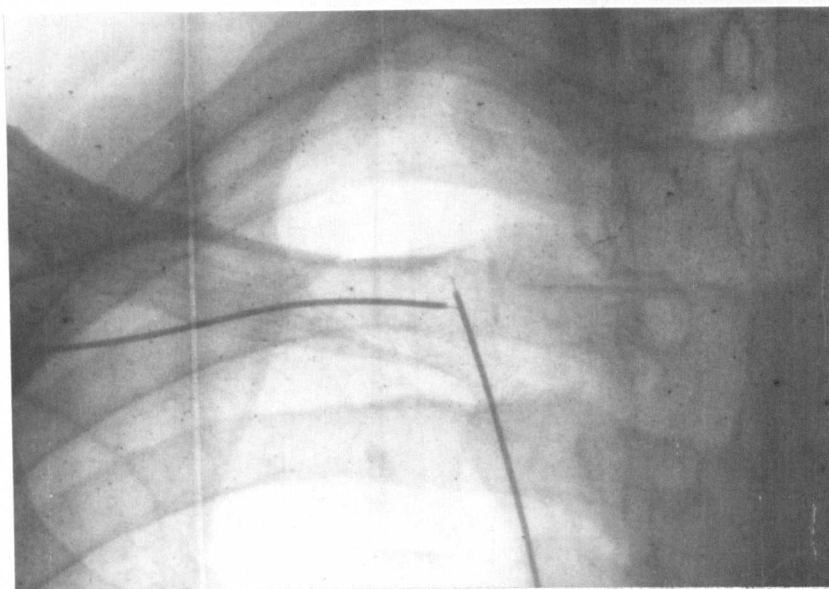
Radiograph showing broken unipolar endocardial electrode-lead system.
